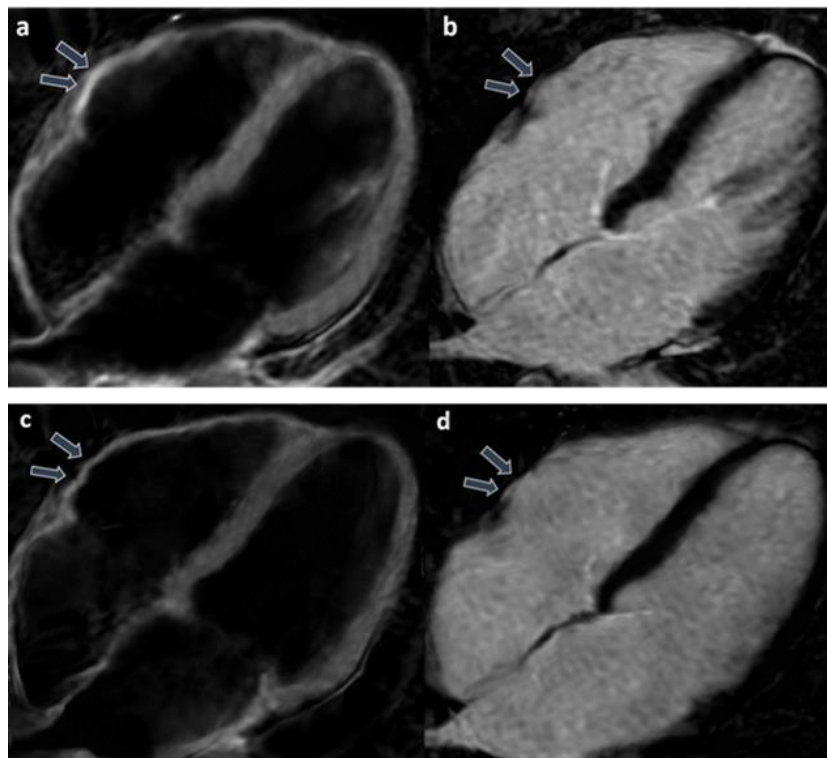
Cardiac magnetic resonance imaging, TIR/T2w and LGE sequences. In the acute setting, increased signal in TIR/T2w sequences as per edema was observed at the level of the basal segments of the free wall of the right ventricle (a, arrows) with corresponding LGE (b, arrows). Control after 3 months shows almost complete remission of the previously described edema (c, arrows) and persistence of LGE at the level of the basal segment of the free wall of the right ventricle (d, arrows). Abbreviations: TIR/T2w: triple inversion recovery/T2 weighted, LGE: late gadolinium enhancement
